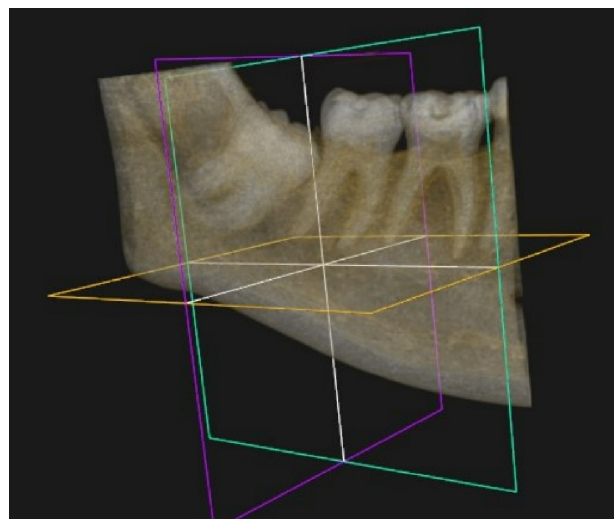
CBCT of impacted molar 48
